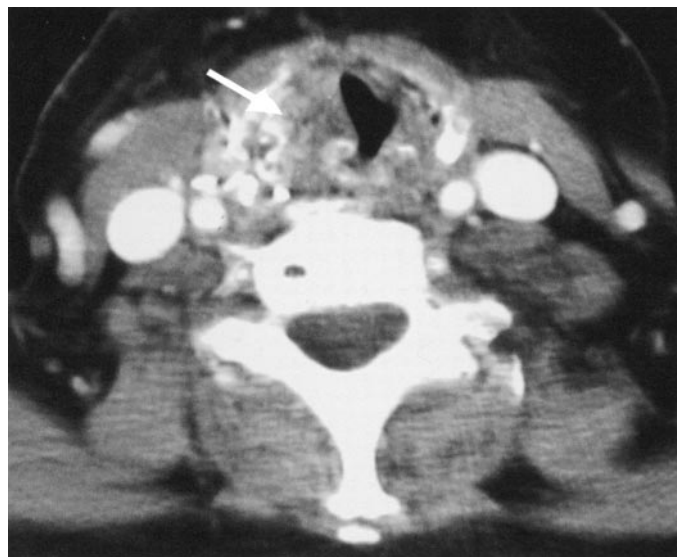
Patient 1. CT scan of the neck 5 d after the acute episode showing tracheal compression by a mass on the right. Lower density inside the mass suggests edema (arrow).
